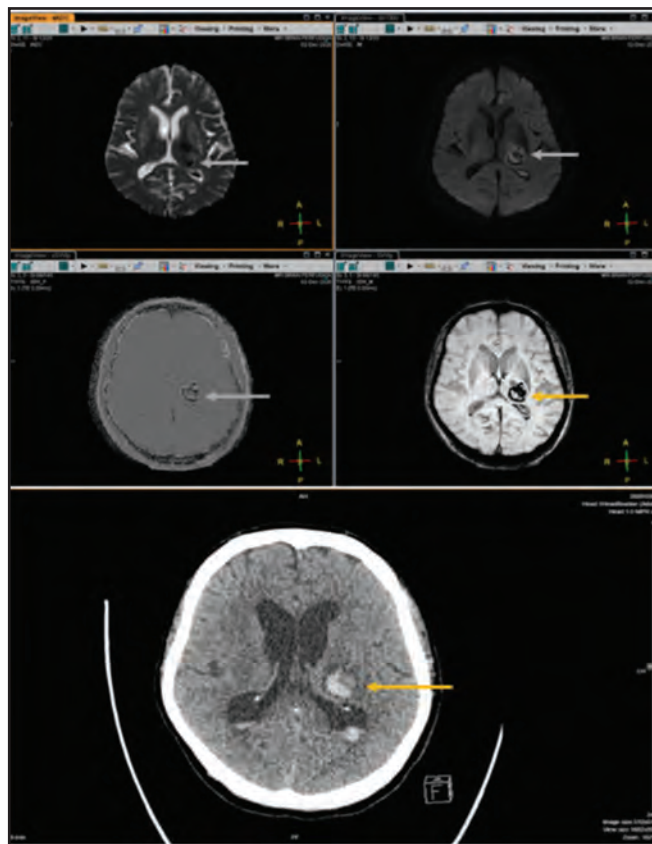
Another hyperacute haemorrhagic stroke patient with left basal ganglia bleed, showing similar central hyperintense area with surrounding hypointense rim (arrows). Comparison to SWI and CT brain of the same patient.
